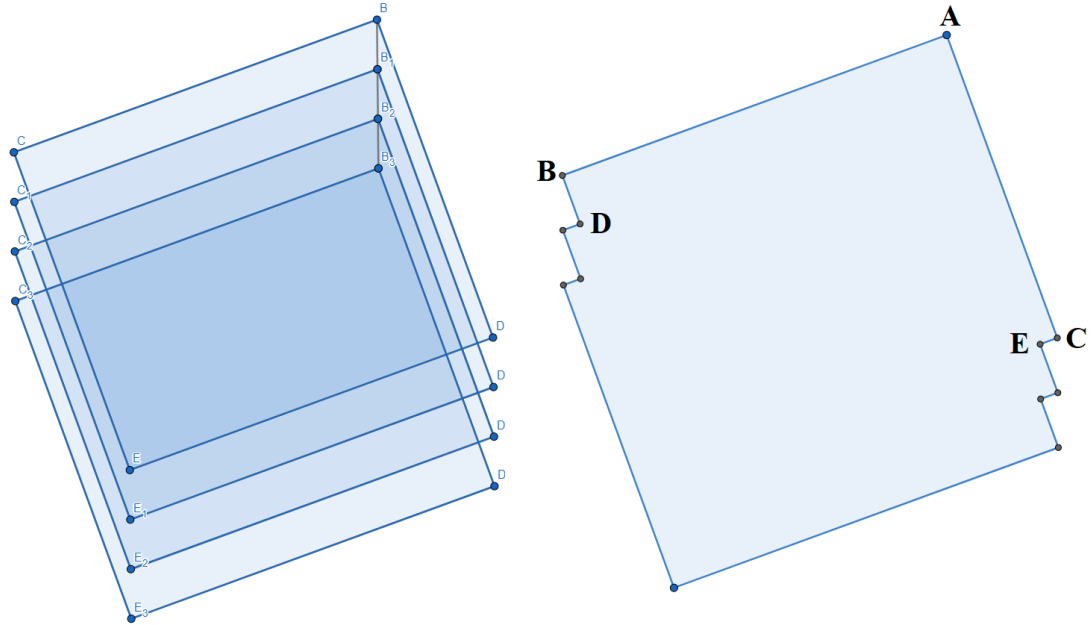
The stereo overlap produced from the frontal column of ultrasound transducers. The left image shows the total view of the four transducers while the right image is only the stereo overlap minus the non-overlapped areas (the lightest top and bottom portions).
